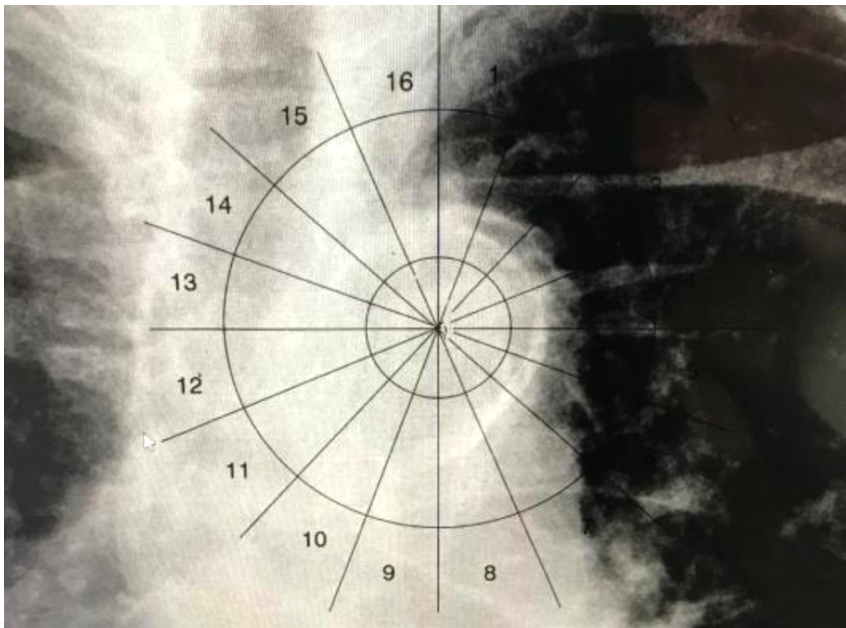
Aortic arch calcification scale attached to a chest X-ray.
